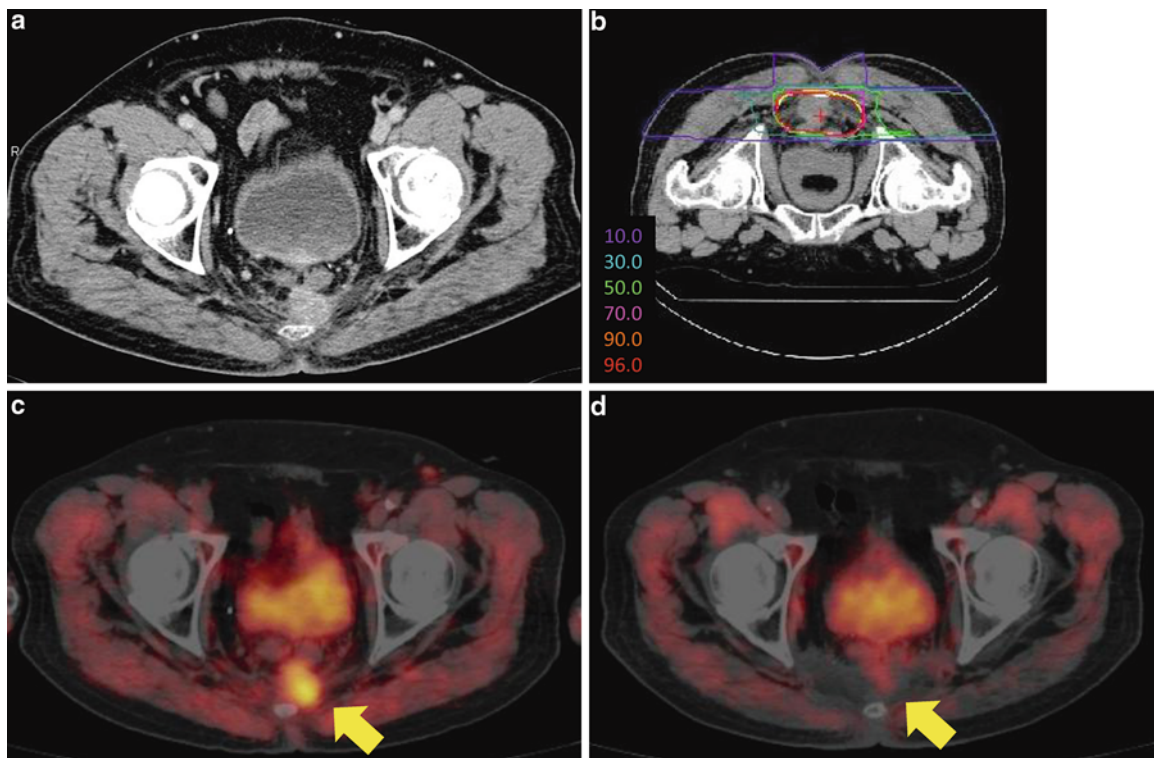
(a) Axial computed tomography before carbon ion radiotherapy. (b) Representative axial isodose distributions. ^{11}C -labeled methionine positron emission tomography images (c) before carbon ion radiotherapy and (d) 40 months after treatment
